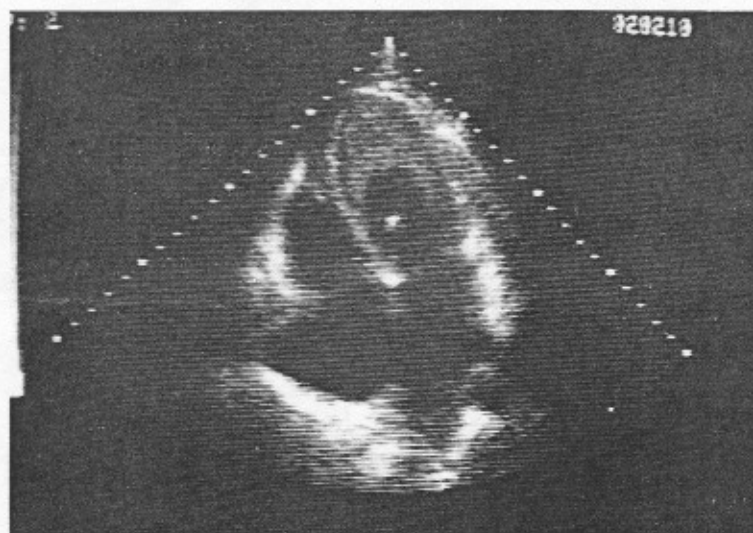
Endomyocardial fibrosis may occur spontaneously in North America. Images are from 56-year-old San Francisco Bay man who had never been outside North America. He had subacute onset of biventricular failure and eosinophilia. Echocardiogram presented typical picture of LV apical obliteration. Contrast injection (agitated saline solution) showed right ventricular apical obliteration also. Doppler examinations showed moderate mitral regurgitation, severe tricuspid regurgitation, and pulmonary hypertension. Surgical resection was attempted but failed. Patient was referred by Drs. Eugene Shafton, Brian Strunk, Kent Gershengorn, and Mark Wexman, San Francisco.
